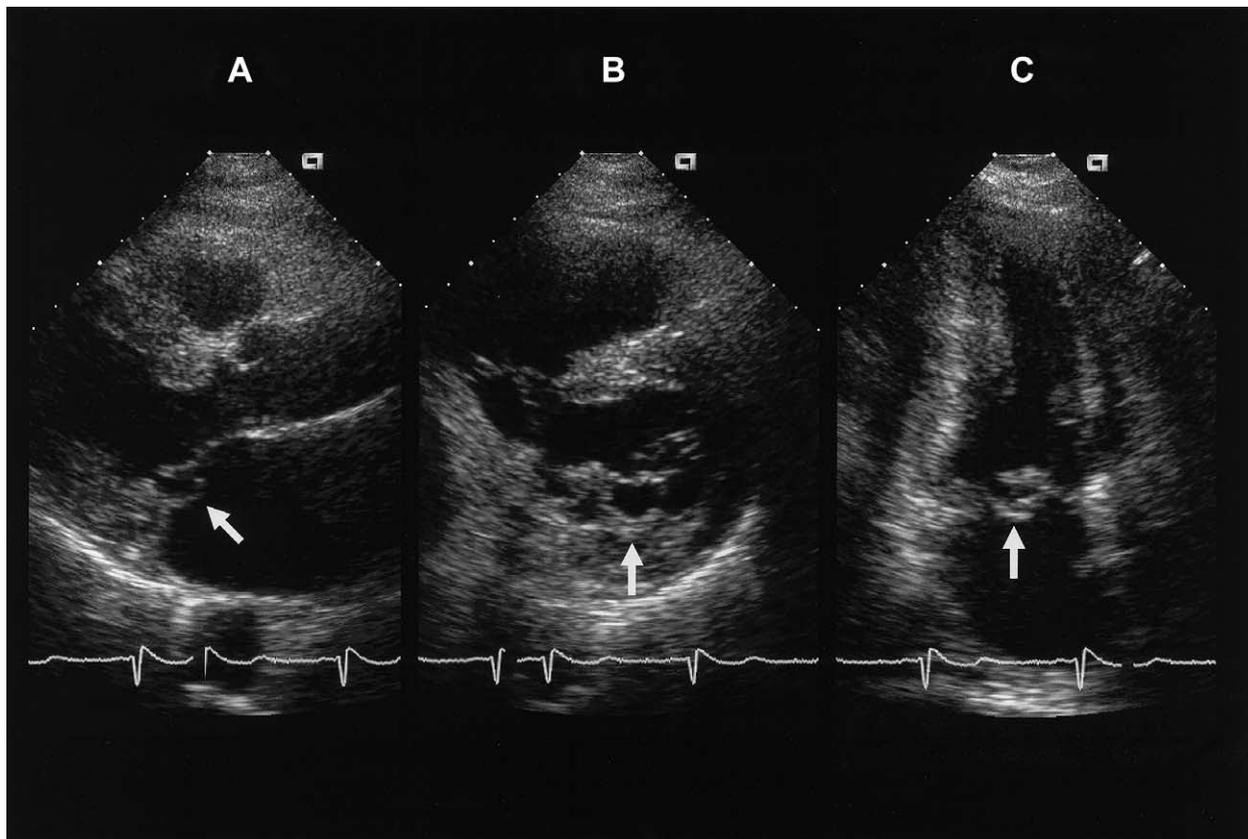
Flail posterior middle scallop (P2). A Parasternal long-axis view showing the flail P2 segment (arrow); (B) and (C) Parasternal short-axis and inter-commissural views, respectively, showing medial doming of flail P2 scallop (arrows) without lateral discontinuity in the commissural areas (P1 and P3).
